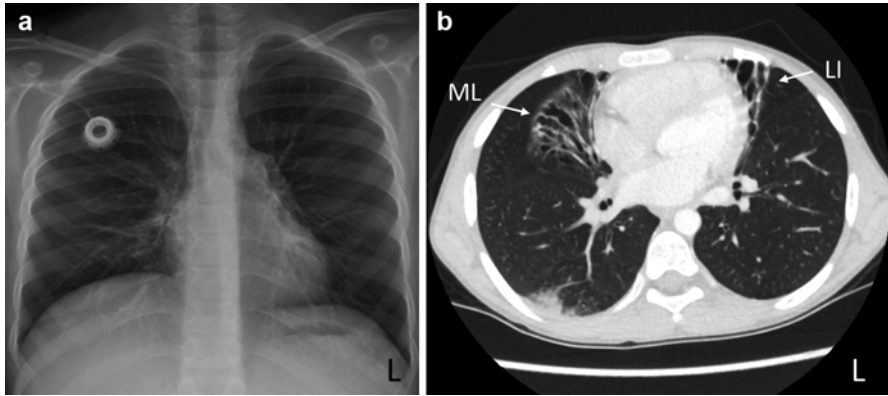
Comparison of radiographs of the lung: plain X-ray (a) and transverse section of computed tomography (b). Bronchiectasis is evident in the middle lobe (ML) and the lingula (LI) with varicose and cystic bronchiectases cut longitudinally (ML) and transverse. Note that bronchiectasis is barely visible in plain chest radiograph (a) (Images kindly provided from Prof. Berthold. Paediatric Radiology, Hanover Medical School, Germany, EU)
